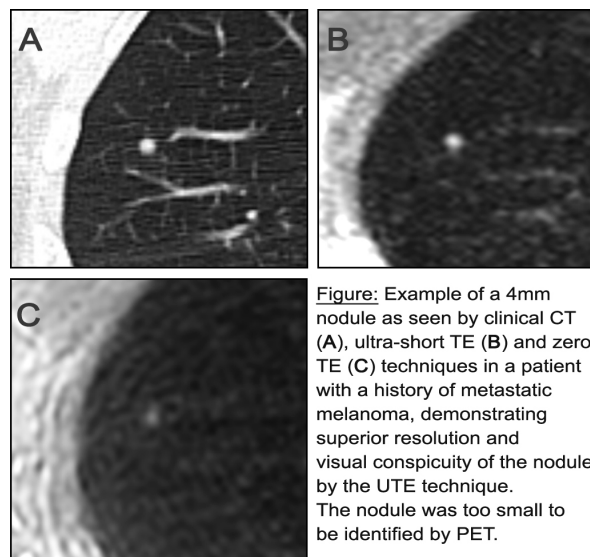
Example of a 4mm nodule as seen by clinical CT (A), ultra-short TE (B) and zero TE (C) techniques in a patient with a history of metastatic melanoma, demonstrating superior resolution and visual conspicuity of the nodule by the UTE technique. The nodule was too small to be identified by PET.
